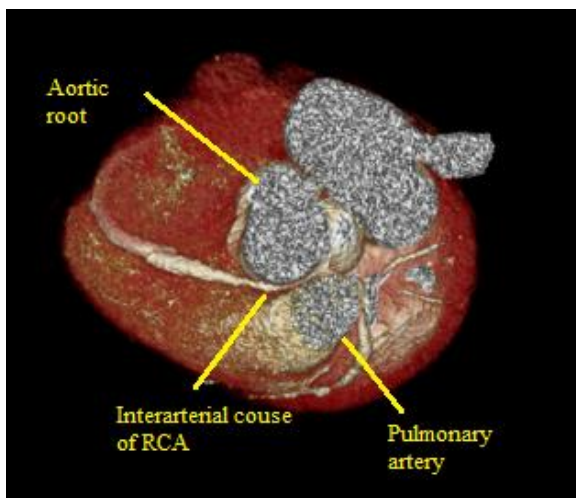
3D CT image showing interarterial course of right coronary artery (RCA) with proximal narrowing.
